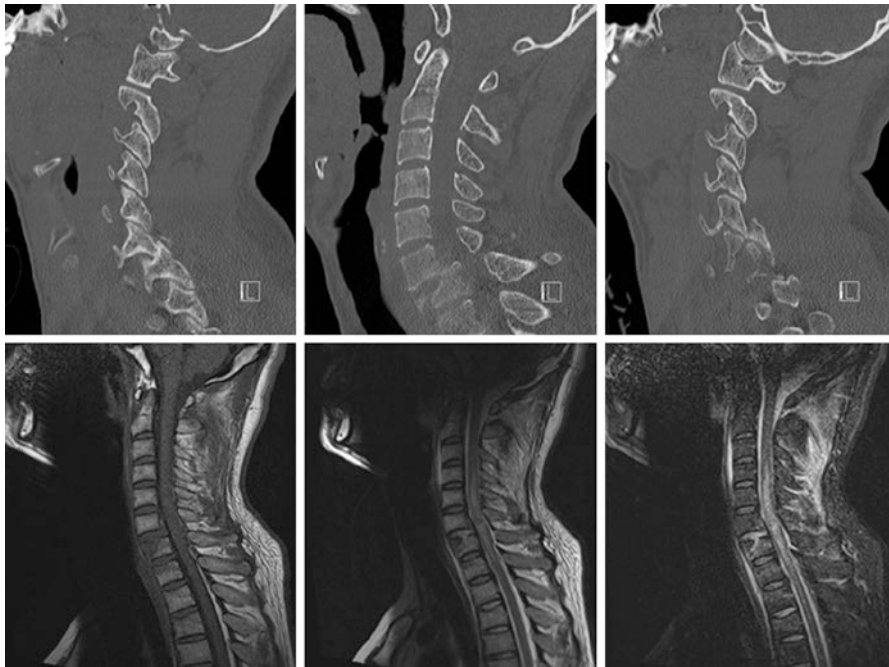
A 29-year-old male involved in a motor vehicle collision. CT exam of his cervical spine revealed a complex fracture-dislocation with bilateral jumped facets, a vertebral body fracture, and a unilateral fractured facet complex. MRI demonstrates realignment after closed reduction and was eventually treated with combined anterior and posterior decompression and fusion
